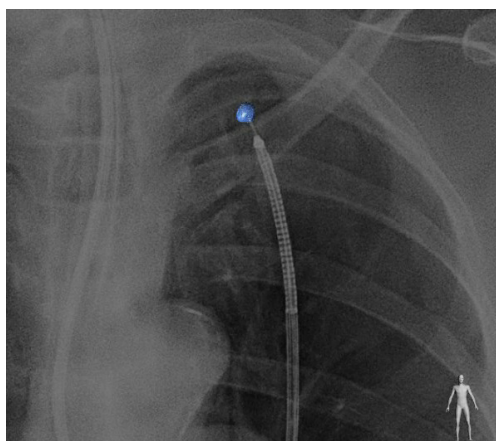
Augmented fluoroscopy during cone-beam computed tomography showing needle biopsy in lesion.
